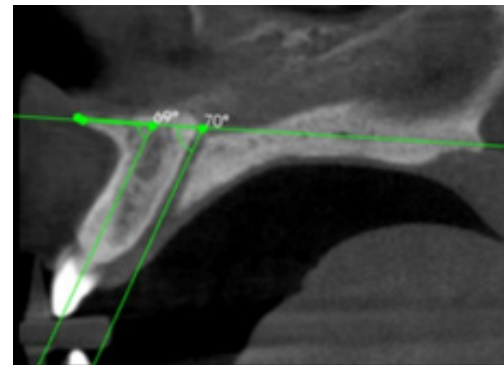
Angular measurements in sagittal section of CBCT
